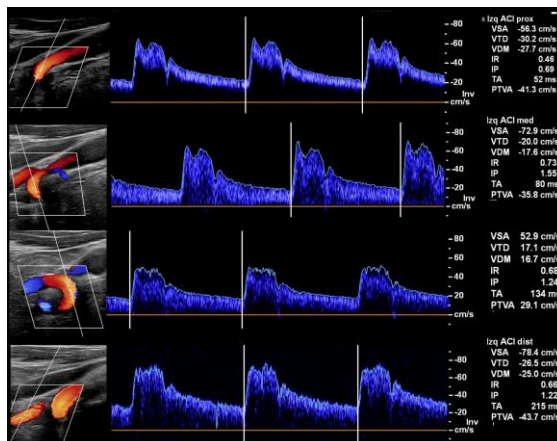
66-years old woman with a history of syncope. ICA in color and pulsed Doppler mode, observing that despite this morphology, all the segments maintain normal speeds, reaching maximum values of 78.4 cm/s, with a variability no greater than 25.5 cm/s.
